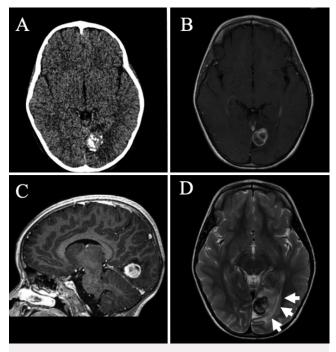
Preoperative imaging. A: Axial CT scan without contrast demonstrating calcified left occipital and parasagittal lesion. B: Axial T1-weighted MR image with contrast demonstrating a tumor with heterogeneous enhancement by gadolinium. C: Sagittal T1-weighted MR image with contrast showing the lesion in the lingual gyrus without the dural tail sign. D: Axial T2-weighted MR image demonstrating the surrounding edema (*arrows*).
